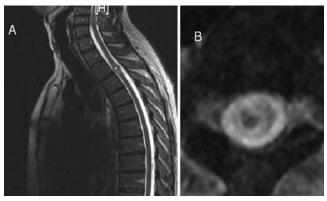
Sagittal midline (A) and axial (B) T2-weighted MR images of a C7–T1 SCCM.
